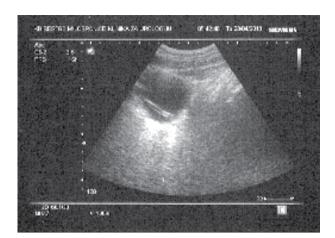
Ultrasonographic image of the urinary bladder showing the foreign body.
